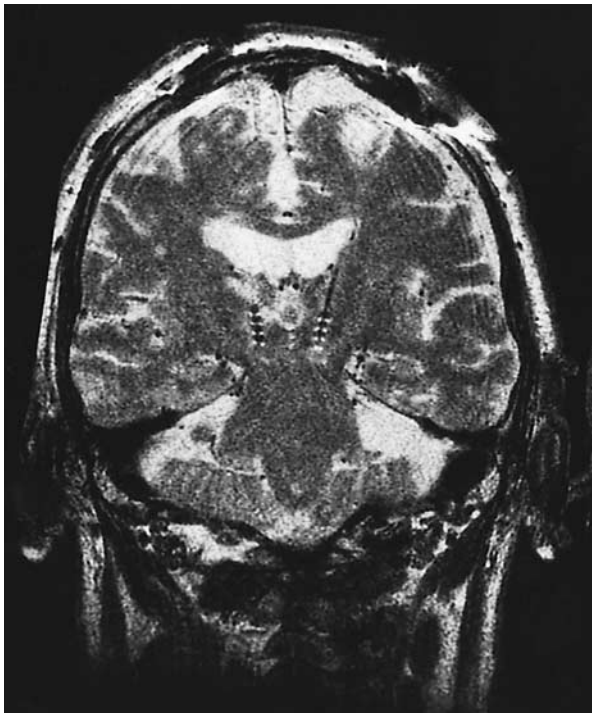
T₂-Weighted MRI Scan Showing Bilateral Quadripolar Electrodes Implanted in the Subthalamic Nucleus.
